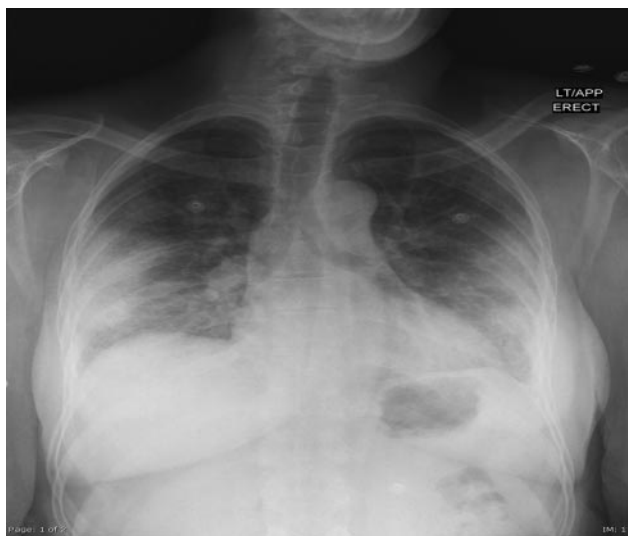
Chest x-ray showing bilateral peripheral air-space disease.
